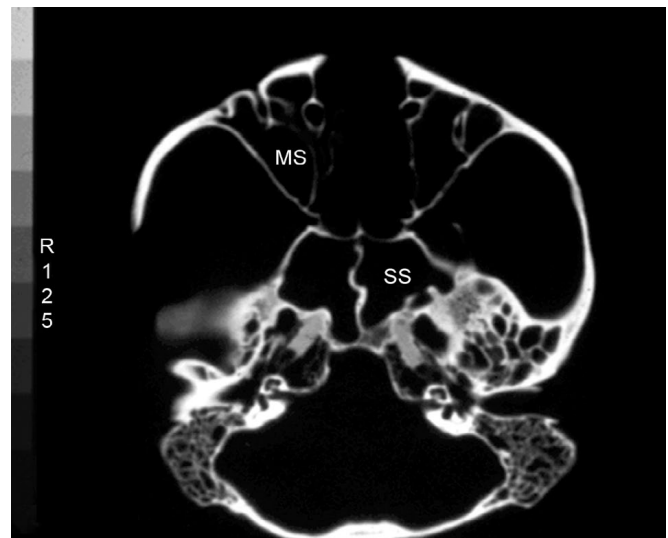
An axial computed tomography scan of a chimpanzee cranium demonstrating distinct maxillary sinuses (MS) and sphenoid sinuses (SS).
